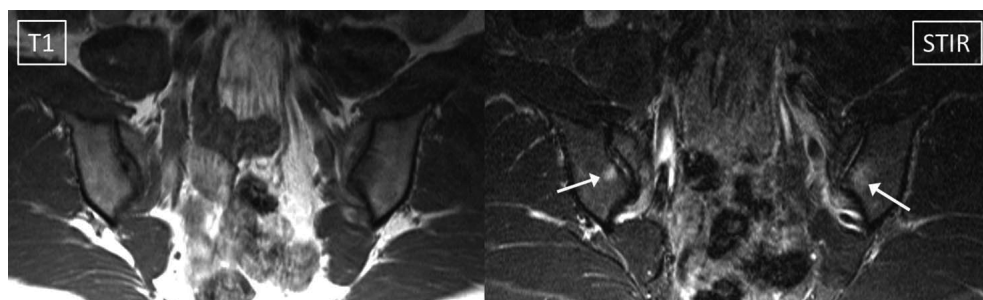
MRI sacroiliac (SI) joints—healthy volunteer. MRI of SI joints in a 35-year-old female health services worker who was an asymptomatic volunteer enrolled as a control subject into an ethics-approved research project. There was no history of pregnancy. The subject was fit and healthy and did not participate in any endurance activities. Clinical evaluation confirmed the absence of any symptoms, signs or risk factors for spondyloarthritis (SpA). The volunteer has been followed for 10 years and remains asymptomatic. The short tau inversion recovery (STIR) sequence shows abnormal increased signal (arrows) in the subchondral bone of both SI joints. The findings were clearly visible on at least two slices bilaterally. The lesions on STIR are small (12 mm on left and 8 mm on right) and are located close to the anterior borders of the SI joints. Some brighter signals in the 'joint space' seen on these and other images are suspicious for cartilage degeneration. Minimal signal change is present on the T1-weighted sequence and no structural damage changes are present. The follow-up MRI performed 8 weeks later as part of the clinical trial was unchanged.
